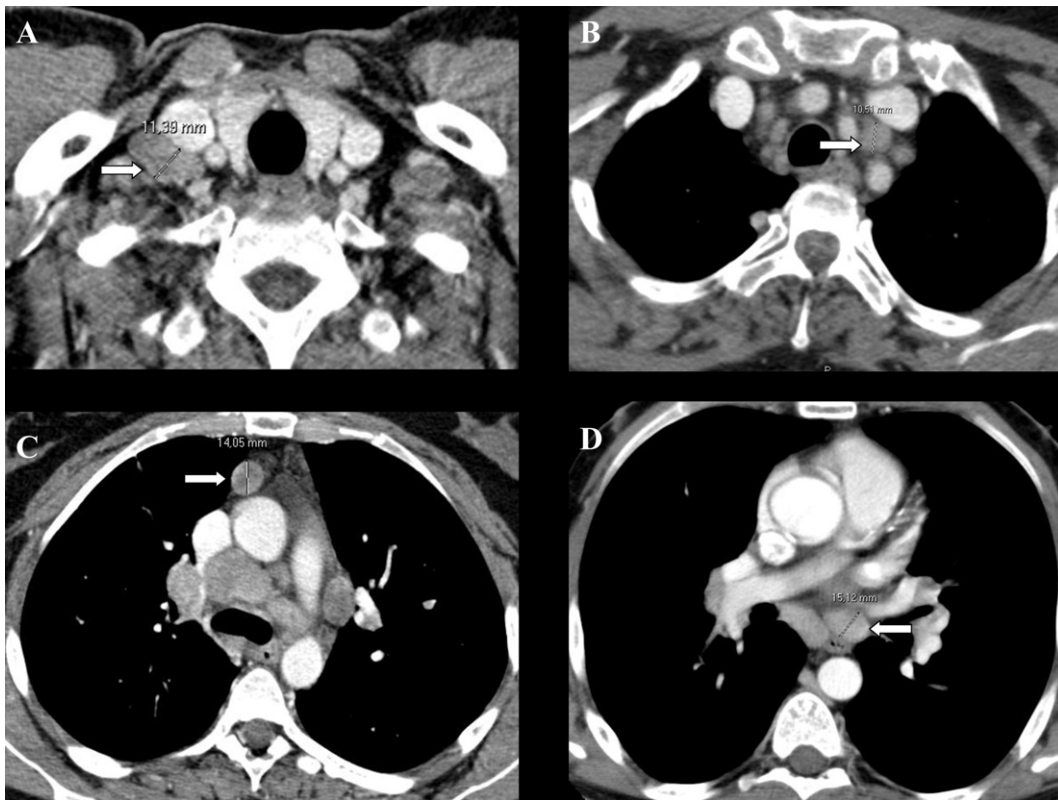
Contrast-enhanced CT of the chest (axial view) from 4 different sarcoidosis patients. Uncommon locations for lymphadenopathy in sarcoidosis (arrows) are stations #1 (A); #2L (B), #3a (C), and 8L (D).
